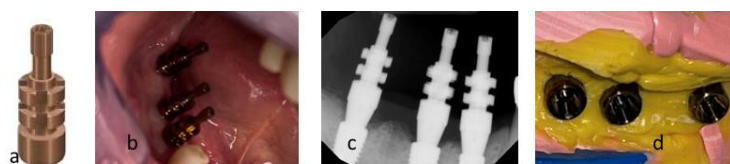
Using MUAs impression coping to take impression at the abutment level: a-MUA impression coping, b- Impression copings secured on MUAs inside the mouth, c-x-ray, d-abutment level final impression
